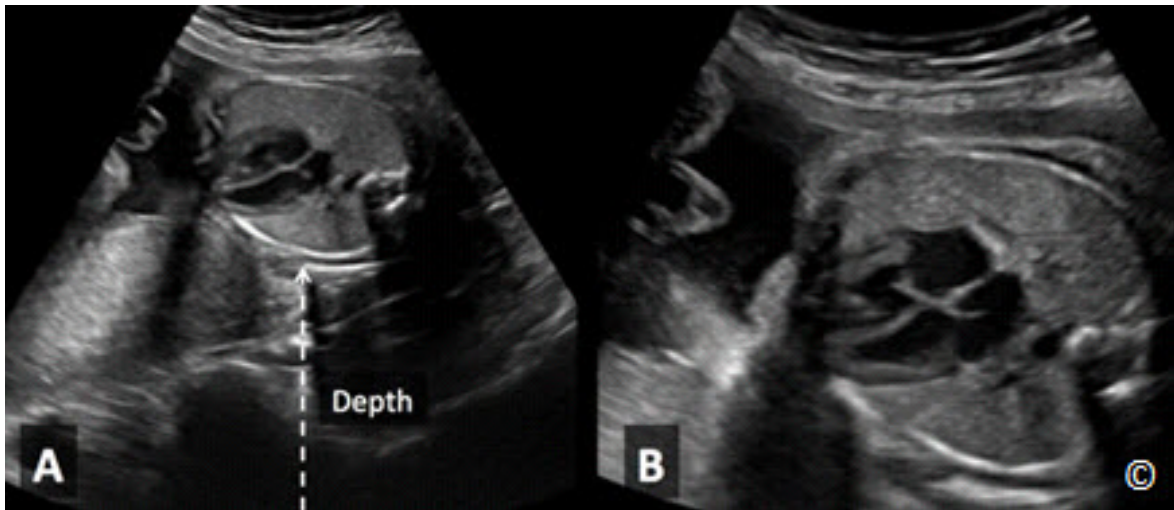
A and B: Ultrasound image of the four-chamber view in the second trimester of pregnancy. Note how small the fetal heart is in A, as the depth of the image is not adjusted (arrow). The depth is minimized in B (same fetus) resulting in image magnification. Minimizing depth also improves frame rate (not shown).
